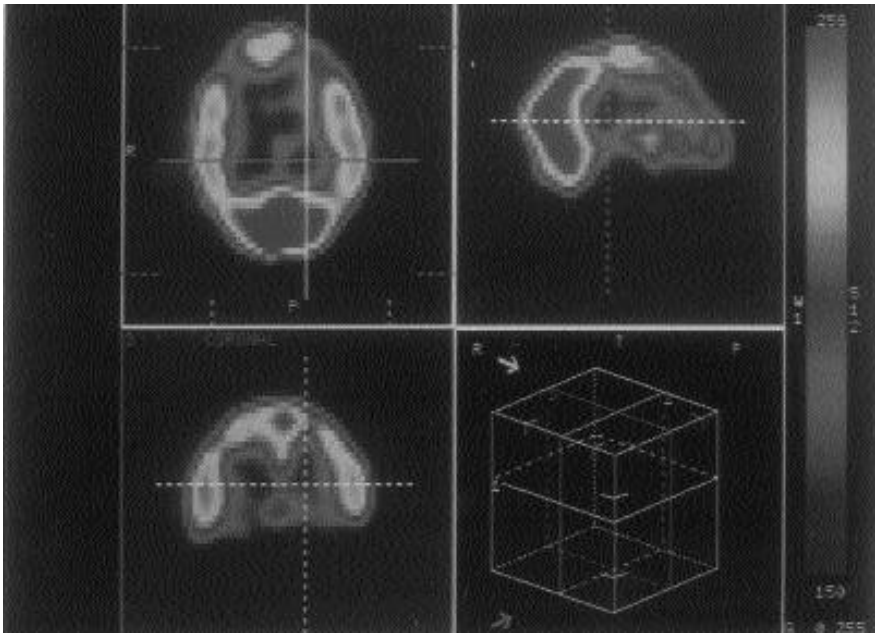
Typical cerebral SPECT scan of a patient with attentional, executive and visuo-spatial disorders: note the hypoperfusion of the frontal (more evident) and right parietal lobe.
